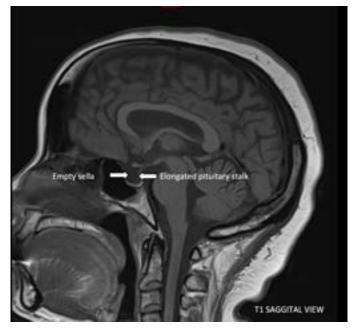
MRI T1 sagittal view demonstrating an elongated pituitary stalk, CSF filled pituitary fossa with a barely perceptible flattened pituitary gland.
